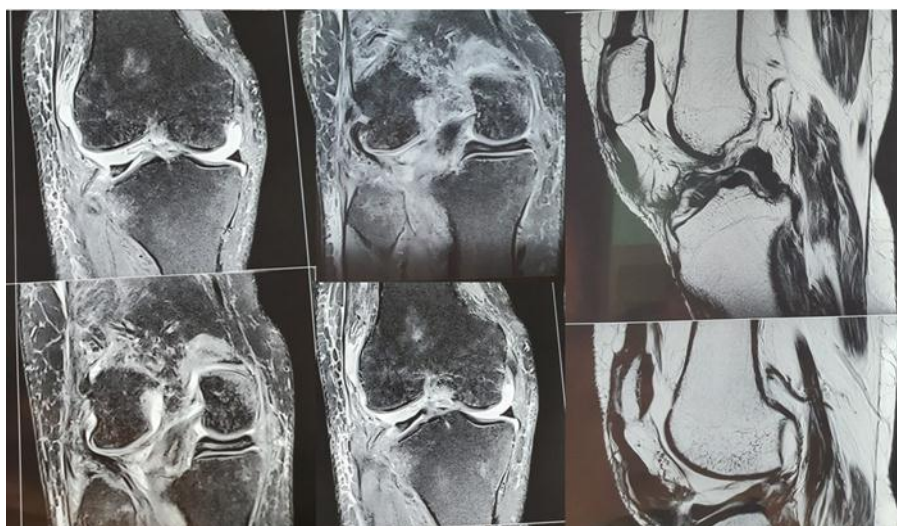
Left side: T2W coronal cuts of MRI suggestive of Anterior cruciate ligament tear, Medial collateral ligament tear, tear of lateral meniscus from menisco-capsular Junction, gerdy’s tubercle fracture, second fracture, depressed fracture of lateral condyle. Right Side: T1W saggital cuts suggestive of Patellar tendon rupture from tibial tuberosity.
